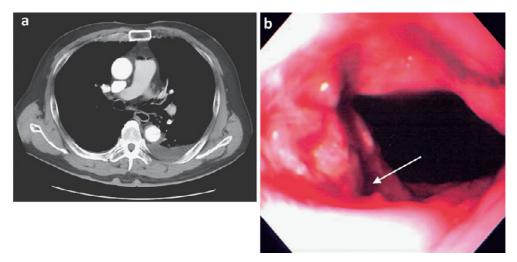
(a) Computed tomography of Patient 1 shows pneumomediastinum with plural effusion.(b): Endoscopic image of the lacerated left posterior wall of the esophagogastric junction (arrow).
